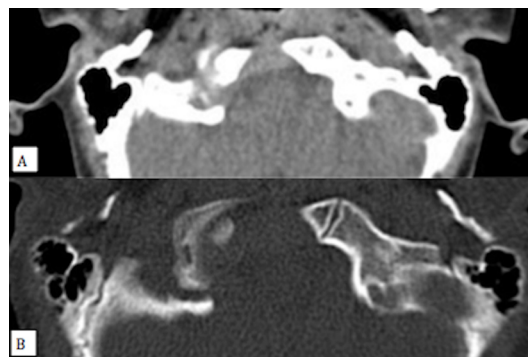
CT axial osseous window (A) and soft-tissue window (B) imaging planes, showing a single osteolytic lesion centred on right occipital condyle.
